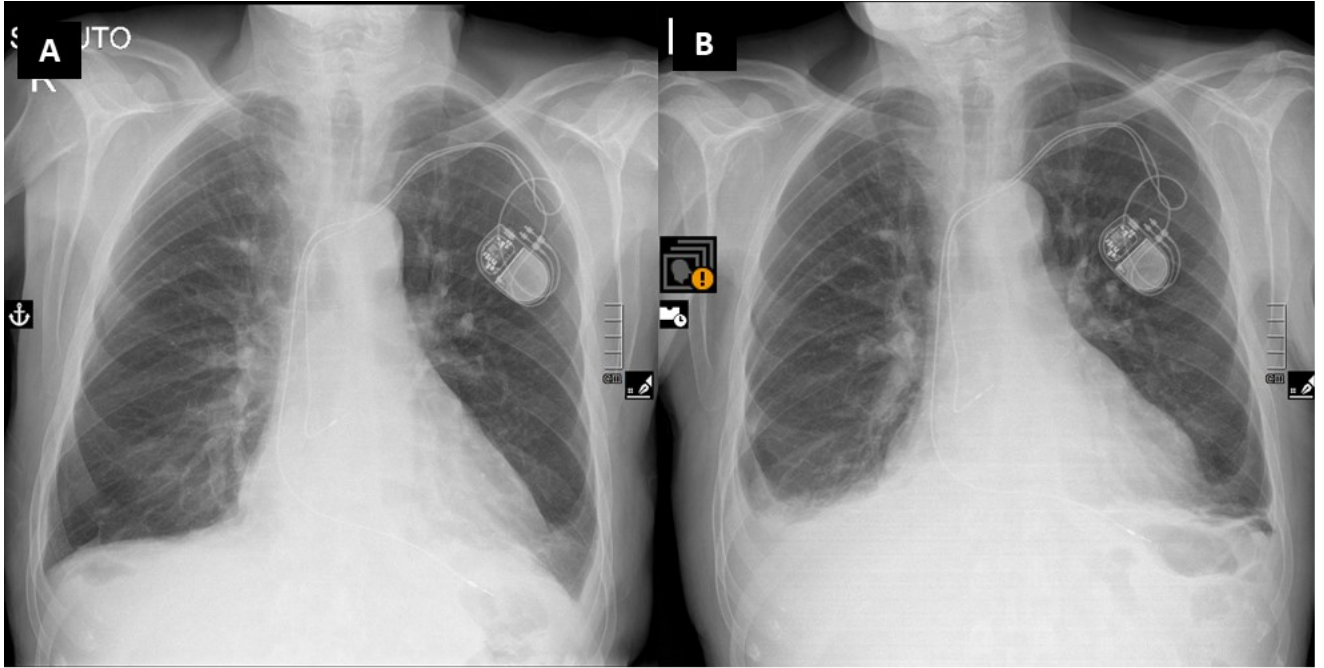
A) Chest X-Ray on admission. B) Chest X-Ray after 2 weeks
